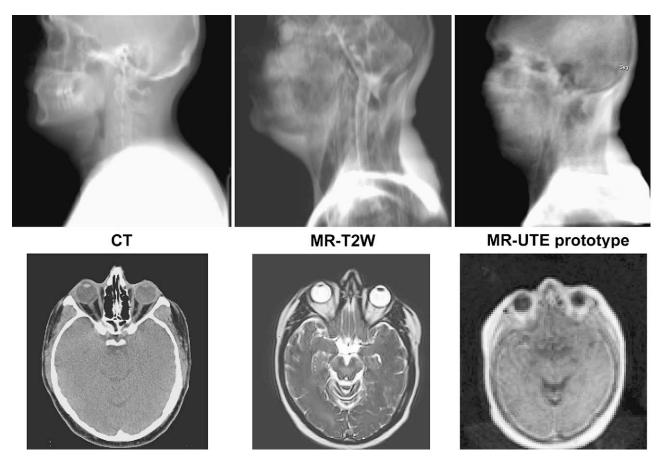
DRRs and slices based on CT, T₂-weighted MR imaging, and a prototype UTE image. The UTE image is a subtraction of the images acquired with 4.76 ms echo time from the image with 0.07 ms echo time.
